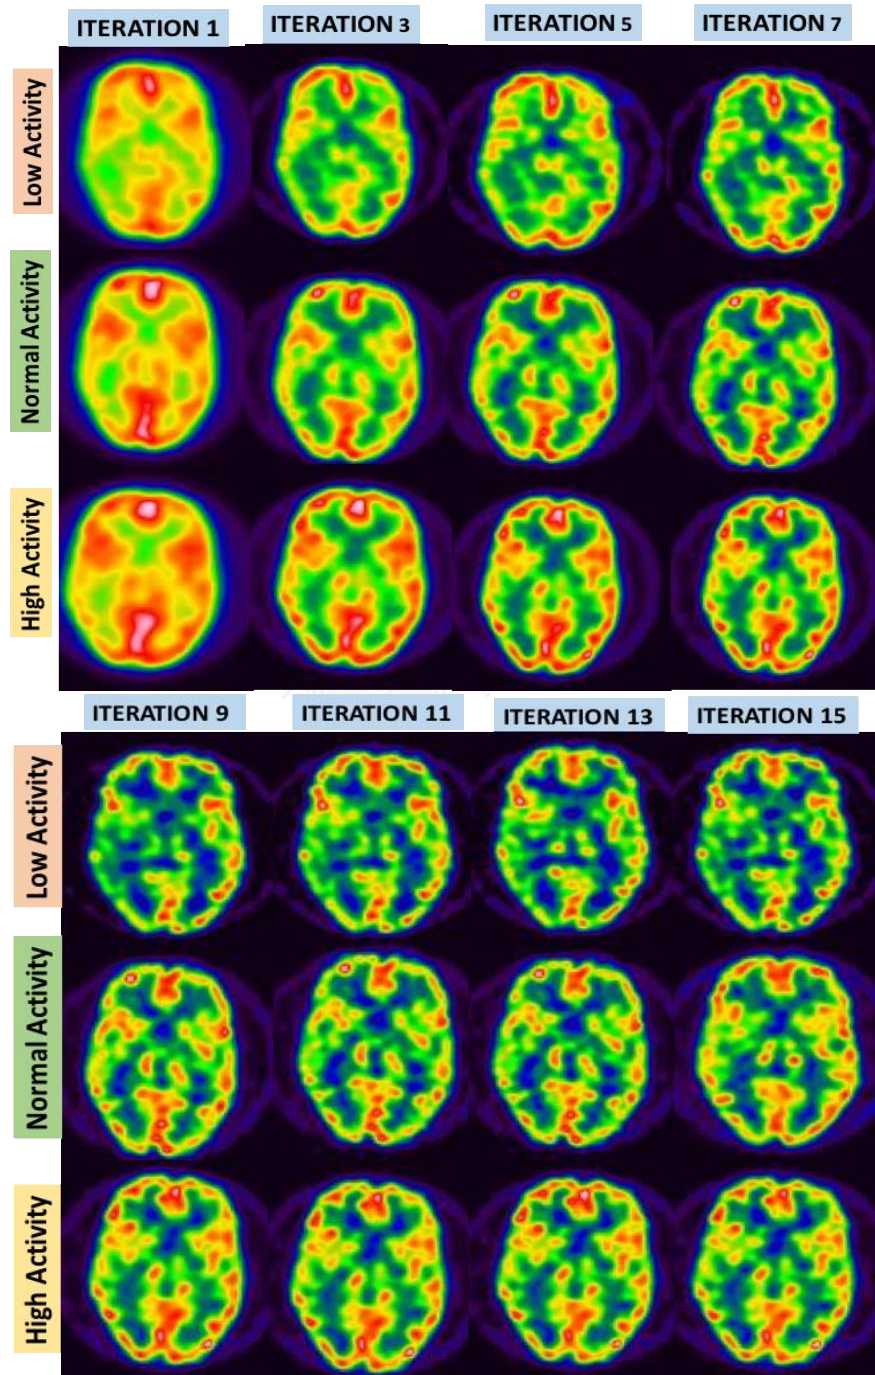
Brain SPECT images by varying number of iterations of 3 activity concentration in OSEM method
